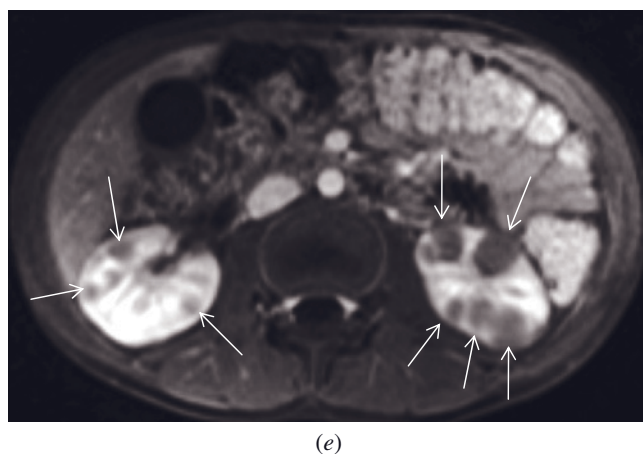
Lymphoma—multifocal renal involvement. T2-weighted breathing-independent SS-ETSE (*a*) and T1-weighted fat-suppressed gadolinium-enhanced SE (*b*) images. Lymphoma masses are mildly hypo- to isointense on T2-weighted images (*a*) and heterogeneous with low-signal-intensity centers (arrows, *b*) on interstitial-phase gadolinium-enhanced images. Incidental note is made of gallstones, which are well shown on the breathing-independent T2-weighted image (arrow, *a*). T2-weighted single-shot echo-train spin-echo (*c*), T1-weighted postgadolinium fat-suppressed hepatic arterial dominant-phase (*d*), and hepatic venous-phase (*e*) 3D-GE images demonstrate multifocal lymphoma (arrows, *d*, *e*) in another patient. The lesions are located in both kidneys and are isointense to the renal cortex on T2-weighted image (*c*). The lesions show less enhancement compared to the normal renal tissue.
